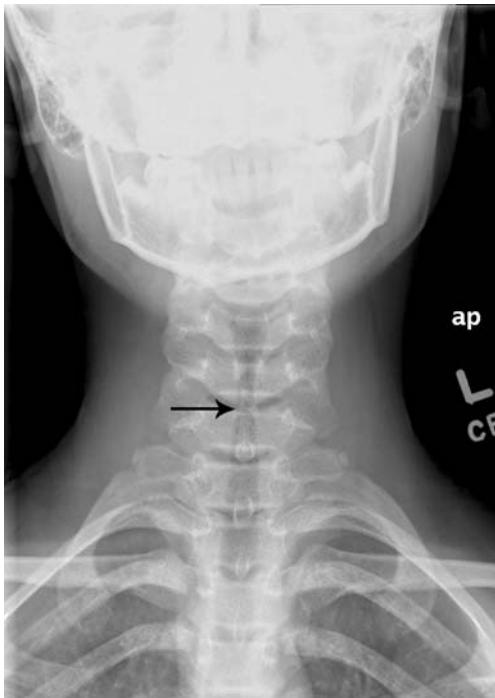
Radiograph, frontal view
